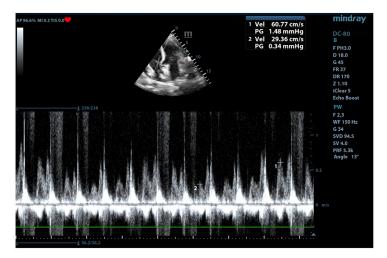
b.2. Respiratory variability of 51% of transtricuspidian E-wave recorded in a patient with cardiac tamponade (PW Doppler, 4-chambers view)
